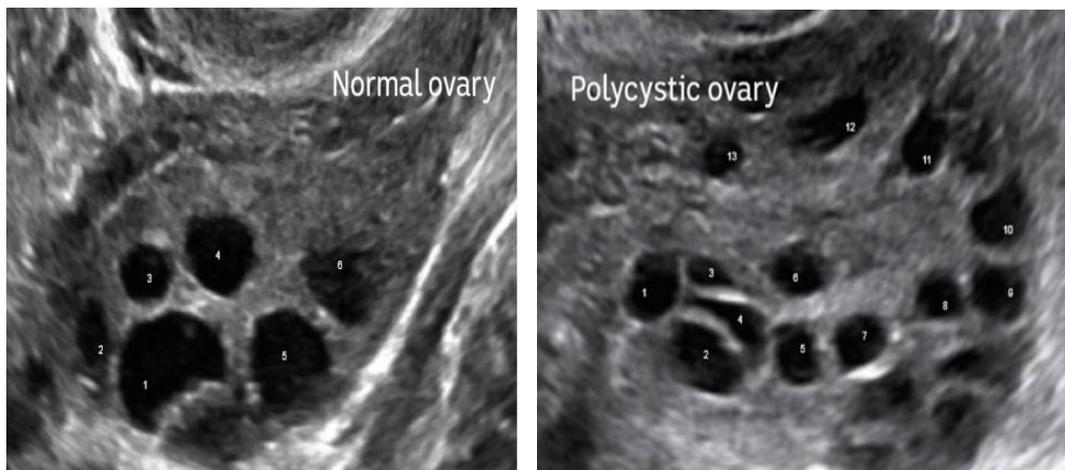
Ultrasound view of Normal ovary v/s polycystic ovary.
